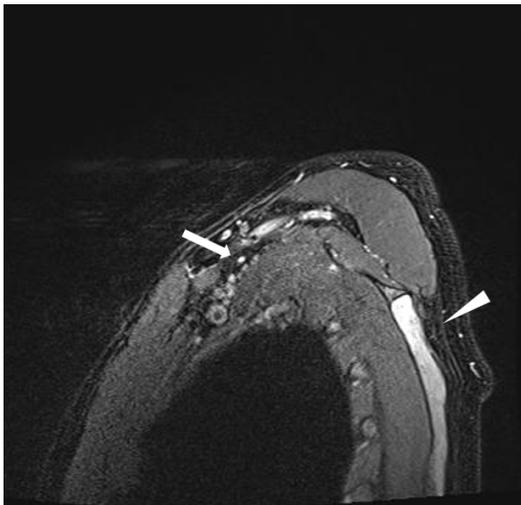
T2-weighted magnetic resonance imaging of the right shoulder with contrast enhancement. High signal intensity was observed in the suprascapular nerve at the spinoglenoid notch (arrow), along with high signal intensity and fatty changes in the infraspinus muscle (arrowhead).
